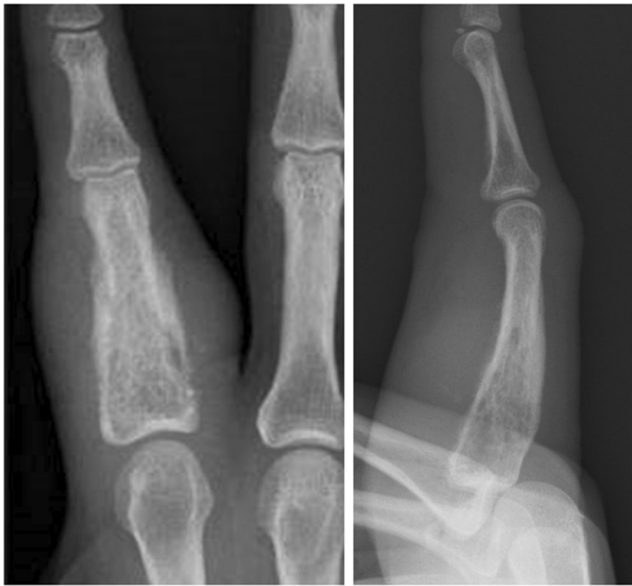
AP and lateral radiographs of the right index finger
